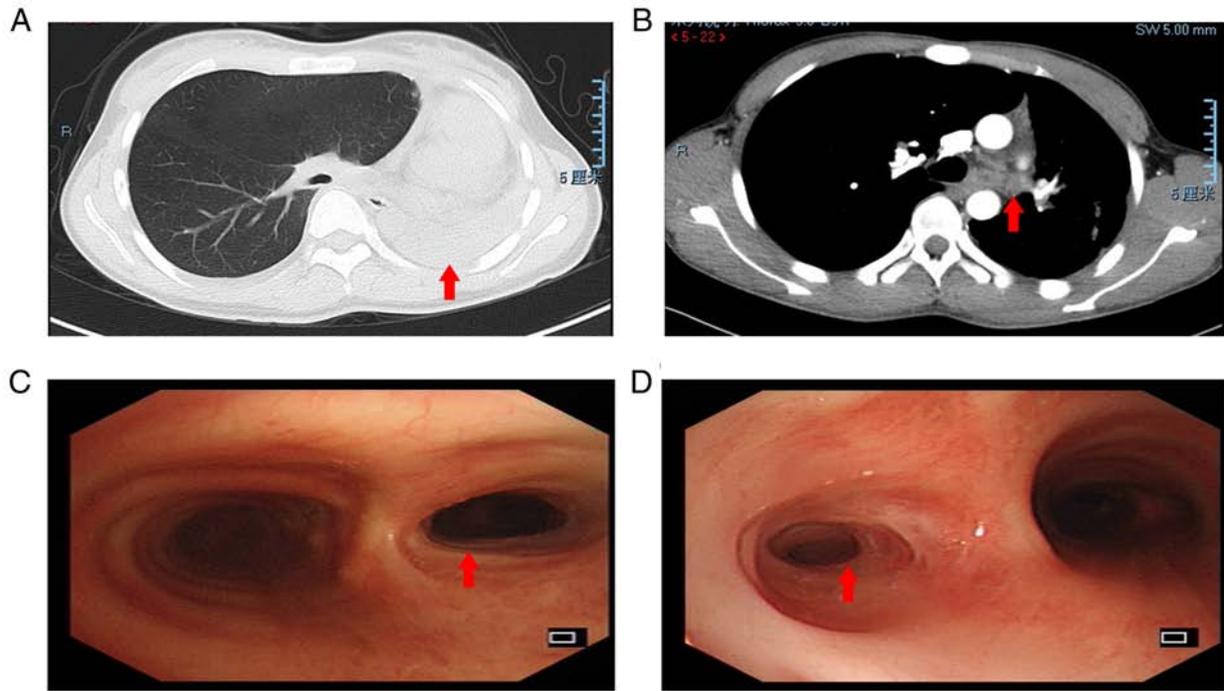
Chest HRCT and bronchoscopy features of patients with PTTS. (A and B) Chest HRCT indicating (A; 19 years old; female; chest routine scan; pulmonary window) left lung atelectasis (red arrow) and (B; 21 years old; male; chest enhanced scan; mediastinal window) left main bronchus mucus plugging (red arrow) due to TBTB (scale bars, 5 cm). (C and D) Diagnostic bronchoscopic appearance of PTTS; (C; 30 years old; female) moderate (red arrow) and (D; 24 years old; female) severe (red arrow) airway stenosis may be observed in the right and left main bronchi, respectively. TBTB, tracheobronchial tuberculosis; PTTS, post-tuberculosis tracheobronchial stenosis; HRCT, high-resolution computed tomography.
